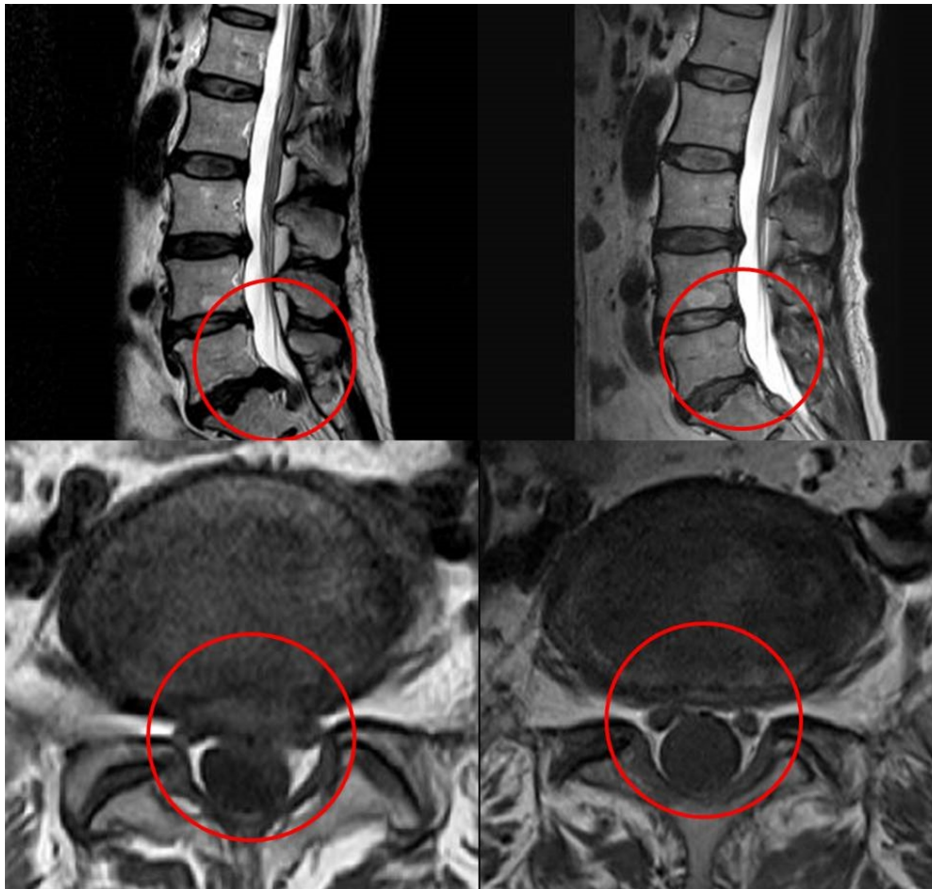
L-spine MRI (Lt. - 2021.02.09, Rt. - 2021.06.17, Upper - Sagittal view, Lower - Transverse view).
